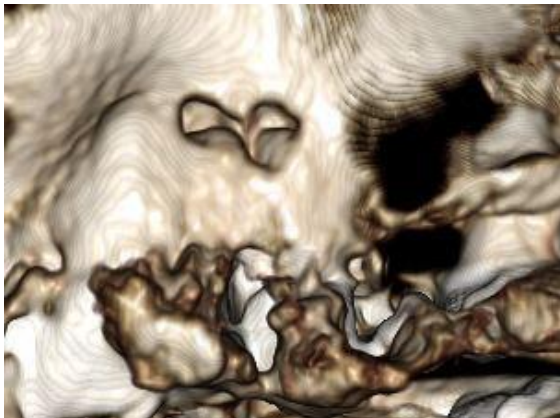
Facial view of CBCT, preoperative CBCT #13
